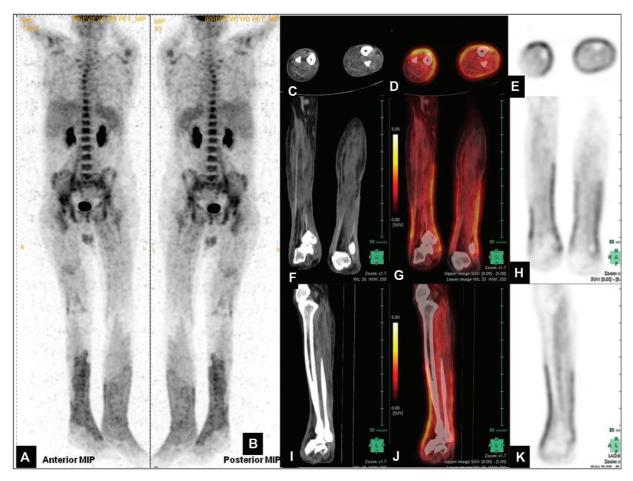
(A, B) Maximum intensity projection (MIP) positron emission tomography (PET) image—anterior and posterior; Computed tomography (CT), PET, and fused PET/CT axial (C–E), coronal (F–H), and sagittal (I–K) images showing diffusely increased metabolic captivity along the fasciae sparing muscles and subcutaneous fat from the region of proximal leg to dorsum of feet bilaterally (standardized uptake value [SUV]max: 4.75). MIP (A, B) images reveal linear hypermetabolism in bilateral psoas muscles (right > left) (SUVmax: 6.15). Low-grade hypermetabolism accompanied by fat stranding was noted around the site of intramedullary nail insertion in diaphysis of right femur (SUVmax: 3.96). Diffuse hypermetabolic bone marrow was noted in the axial skeleton (SUVmax: 5.55). Rest of the whole-body survey was unremarkable and showed physiological tracer distribution.
